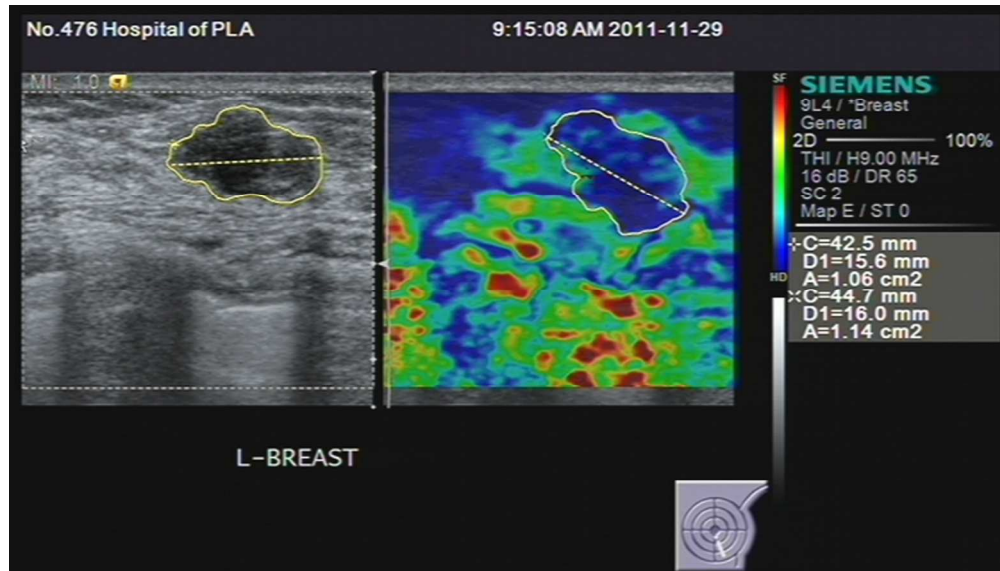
The image of a 45-years old patient with invasive ductal carcinoma. The left picture showed a B-mode ultrasonography locating the region of interest (ROI). The right picture showed the elastography of the breast lesion, with the blue color indicated a harder tissue and the red color indicated a softer tissue.
